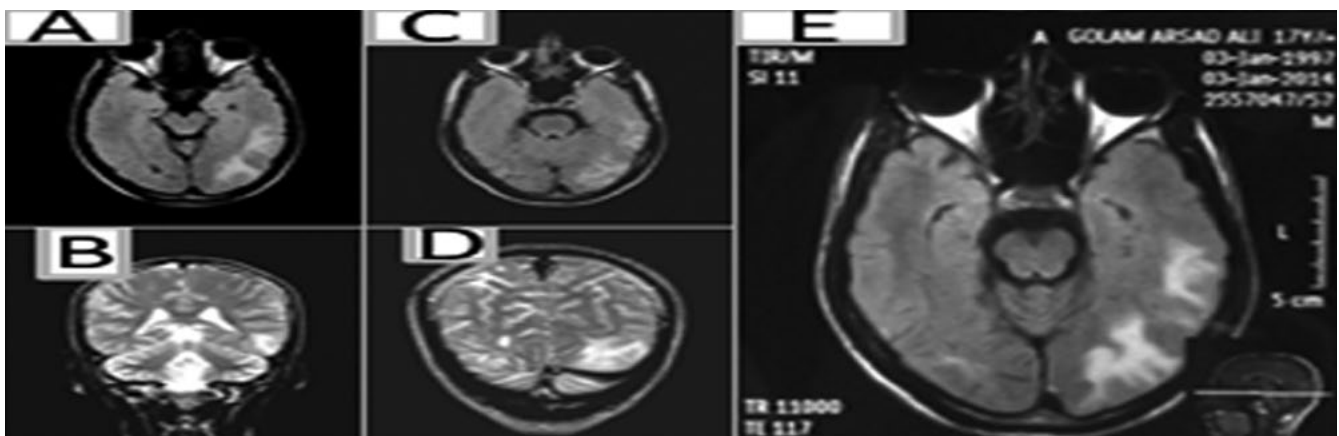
MRI brain screening study: T1W (A and C); T2W (B and D); FLAIR (E).
